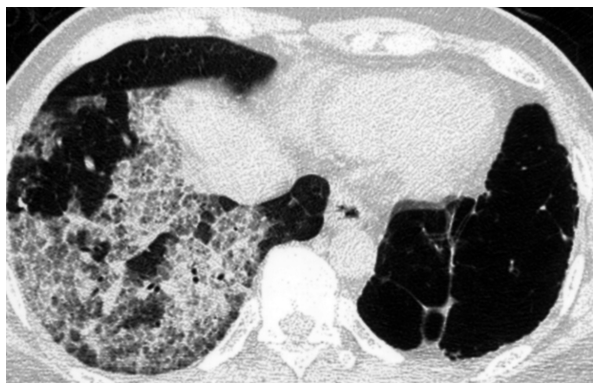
High resolution computed tomography of the chest showing patchy areas of ground glass opacities with prominent septal thickening in the RLL. Bullous emphysema in the left lung is noted.
